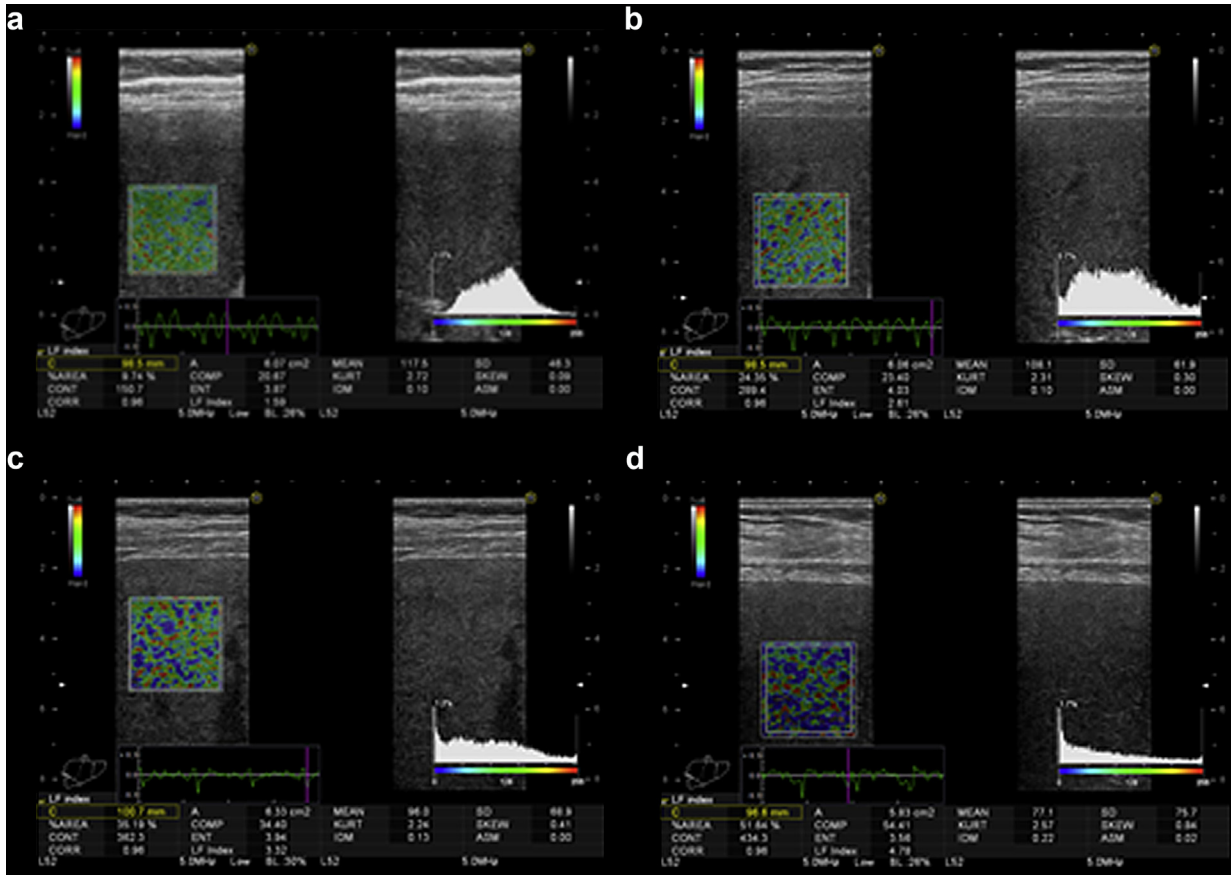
SE images of different stages of liver fibrosis in patients with chronic hepatitis C. The histogram displays the color dispersion in the region of interest. The x-axis shows the color scale of the elastogram, coded from 0 (dark blue) to 255 (dark red); the y-axis shows the percentage of each color. LFI index can be calculated on the ultrasound device. F1 (a), F2 (b), F3 (c) and F4 fibrosis stage (d).
